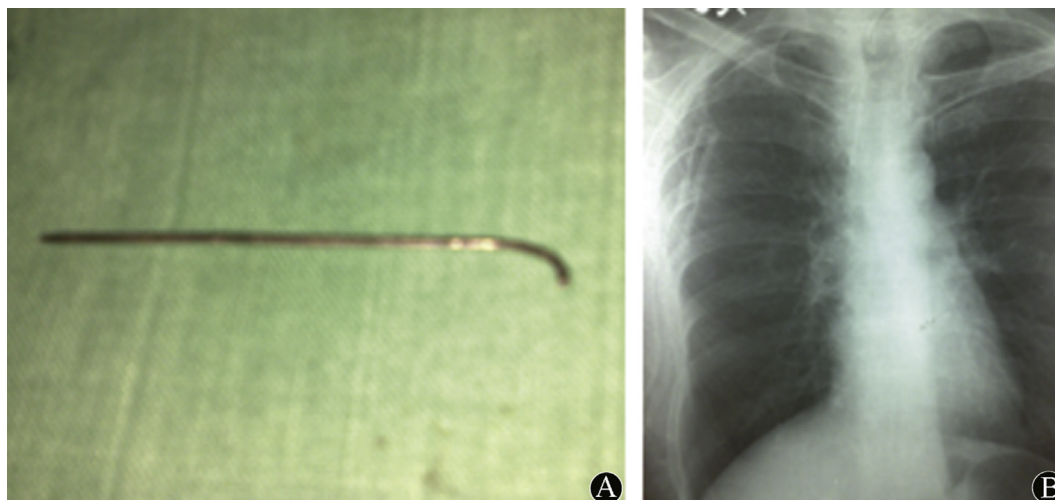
A and B. Removed K-wire and immediate postoperative radiograph.
